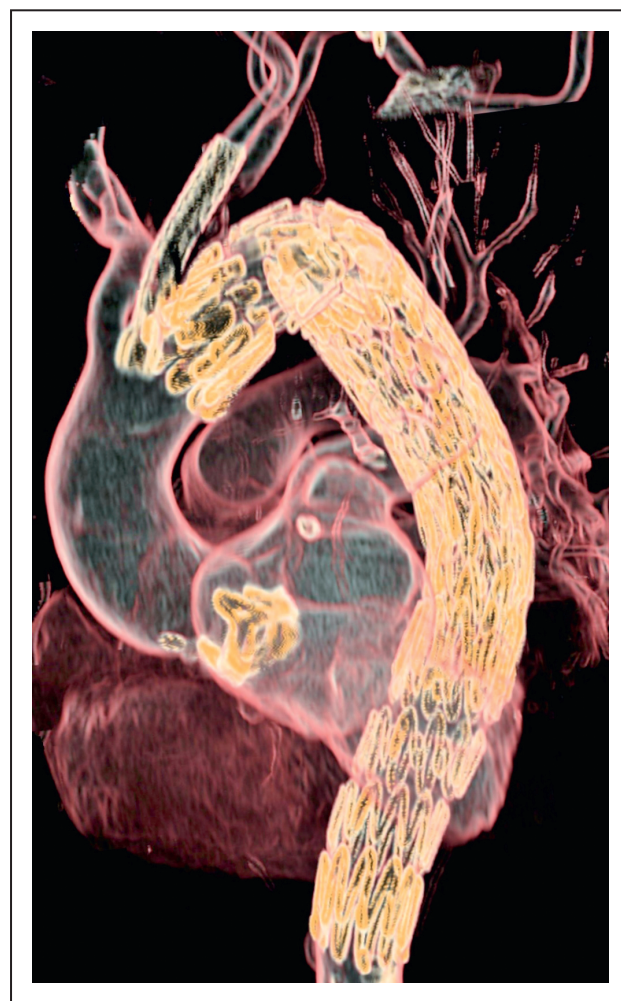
CTA shows a patent stent graft after successful TEVAR of an rDTAA with placement of a chimney stent in the LCCA. CTA, computed tomography angiography; LCCA, left common carotid artery; rDTAA, ruptured descending thoracic aortic aneurysm; TEVAR, thoracic endovascular aortic repair.
